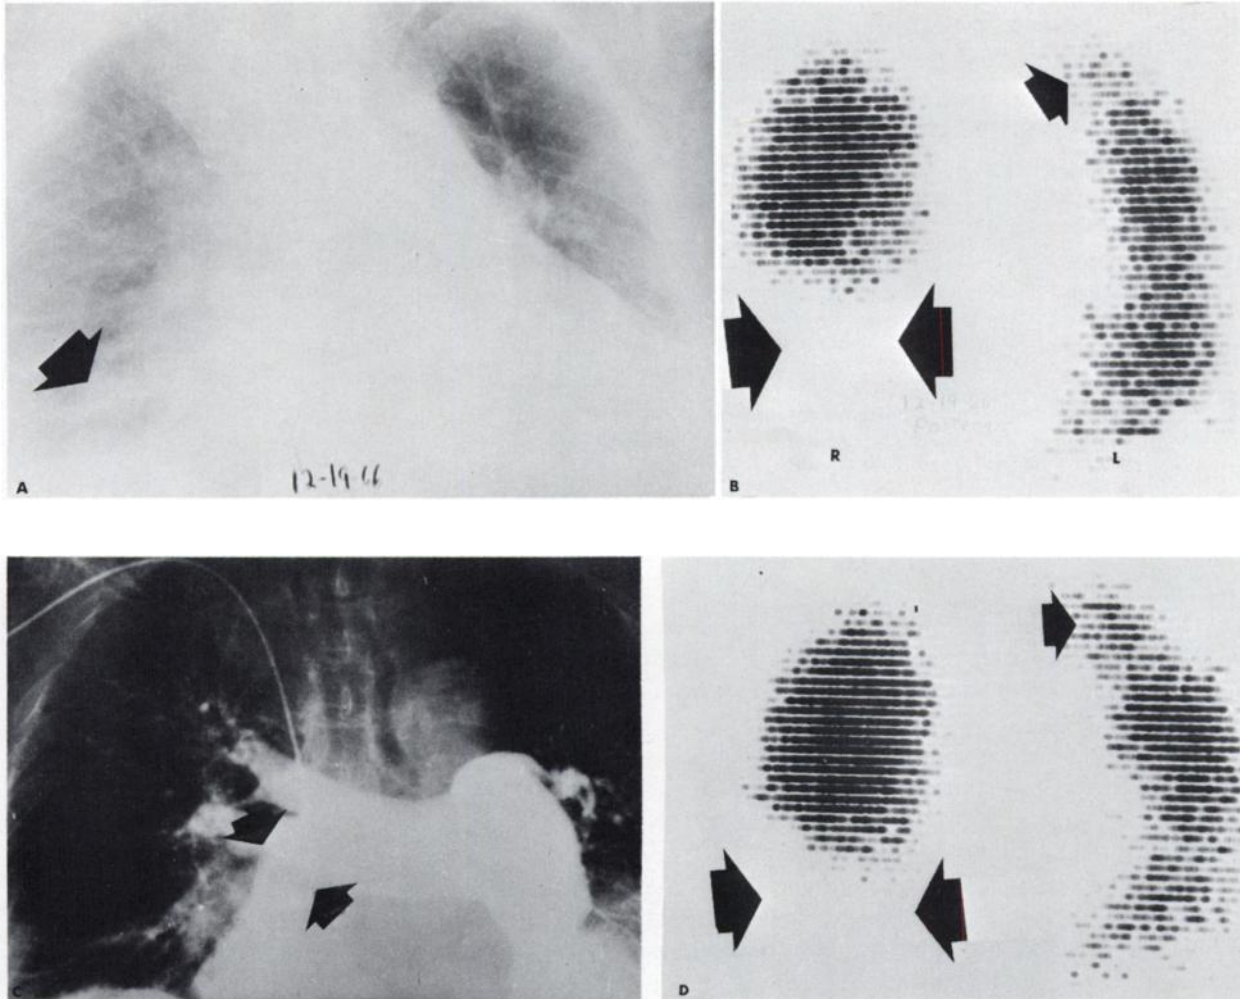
Case 4. Bilateral pulmonary emboli in 81-year-old female with pre-existing cardiopulmonary disease. A: Chest roentgenogram reveals cardiomegaly and vascular engorgement. Right lower-lobe infiltrate is also present. B: Posterior lung scan shows large perfusion defect in right lower lobe (large opposing arrows) and smaller defect at left apex (single smaller arrow). C: Pulmonary angiogram demonstrates complete occlusion of right lower-lobe pulmonary artery (opposing arrows) as well as relative avascularity of left upper lobe. D: Follow-up posterior lung scan 2 weeks after previous study shows little or no change in right lower lobe (opposing arrows) and left apical defect (single arrow).
